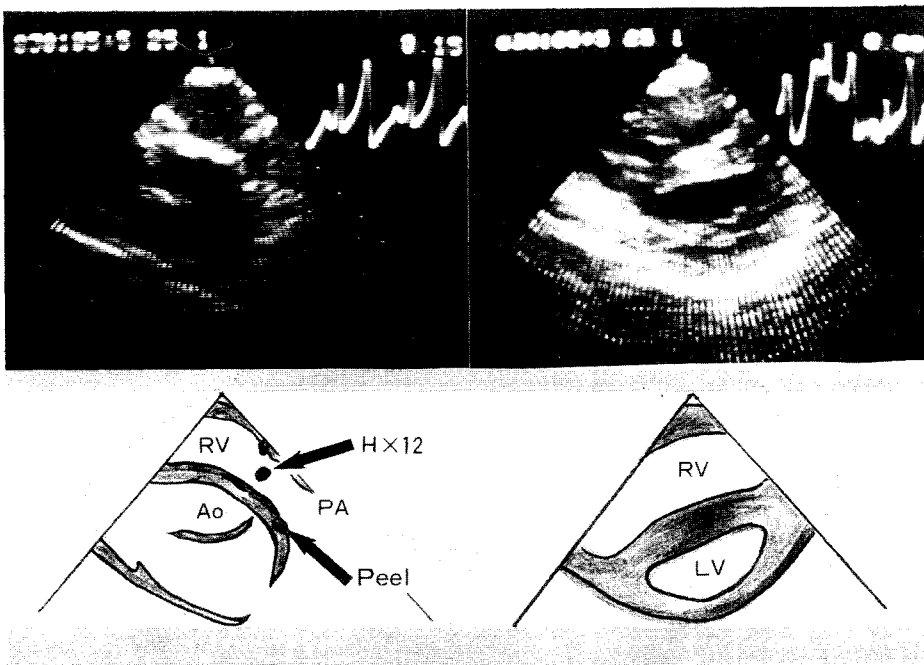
Two-dimensional echocardiograms of case No.3 demonstrate calcified Hancock valve, valvular stenosis and marked left ventricular deformity.
